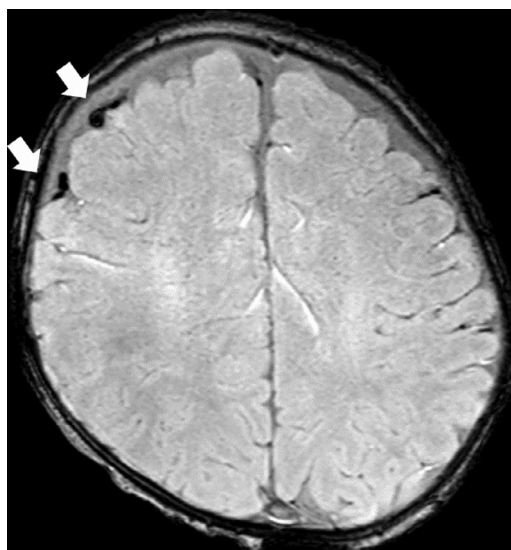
SDH with thrombosed subdural veins and “lollipop” sign. Axial SWI image from a brain MRI examination of a 9-week-old male subjected to AHT, who presented with an apneic episode, demonstrates a right SDH with thrombosed veins and a “lollipop” sign (arrows).
